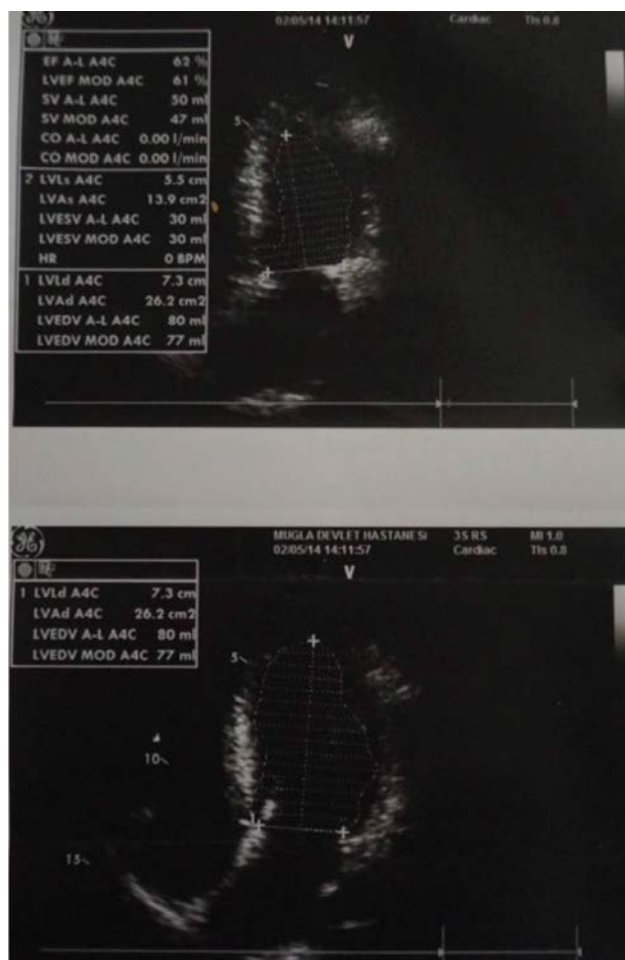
Echocardiogram of the Case Post-Treatment
